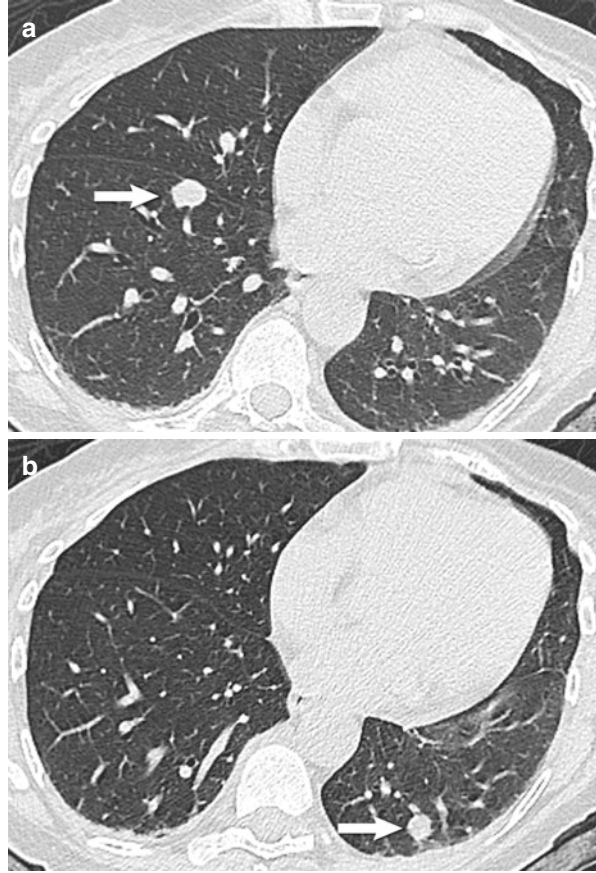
A 64-year-old female status post renal transplant with lung PTLD. (a, b) Noncontrast chest CT shows multiple well-defined lung nodules (arrows) in a lower lung distribution, the most common appearance of pulmonary PTLD
